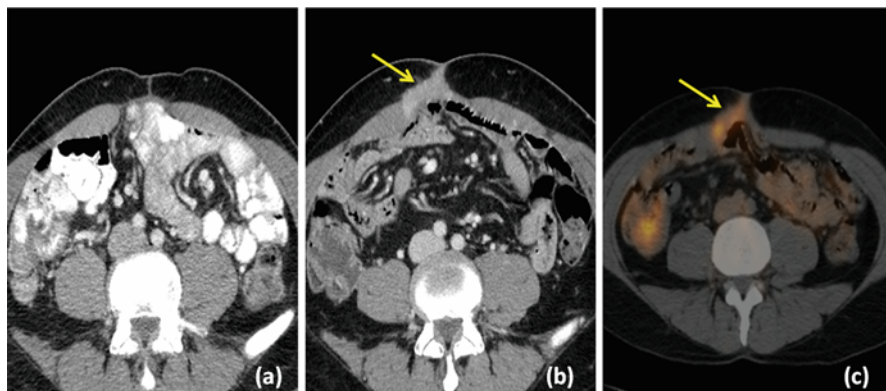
Regional tumor recurrence in the periumbilical abdominal wall. Short-term postoperative CT exam (a) and 2-year follow-up postoperative CT (b) and PET/CT (c) exams at the same level. Note the new mass (yellow arrow) in the periumbilical abdominal wall region overlying the small bowel loops which is shown to be PET FDG positive (yellow arrow)
